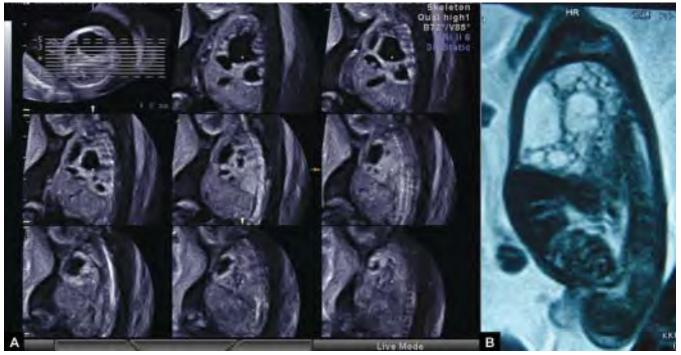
Congenital diaphragmatic hernia at 16 weeks. Tomographic ultrasound image. Typical Bochdalec hernia is seen. Tomographic image clearly shows oppressed and hypoplastic left lung, heart replacement to the right, and the stomach inside thoracic space
